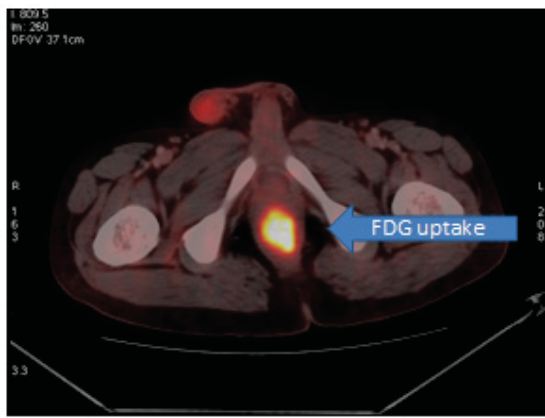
PET/CT scan of patient before CRT showing increased uptake in lower third of rectum (SUV_{max} 16.3)
